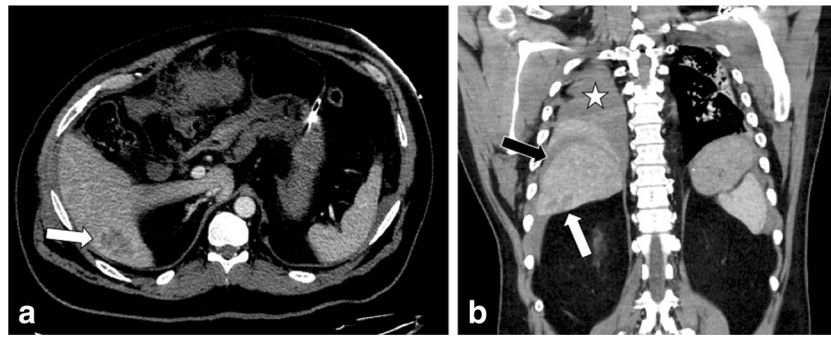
Hepatic traumatic pseudohemangioma. Axial (a) and coronal (b) contrast-enhanced CT demonstrate a rounded hypoattenuating region in the posteroinferior right hepatic lobe with the suggestion of peripheral nodularity (white arrows). On the axial image, the morphology is suggestive of a hemangioma; however, coronal image demonstrates a
